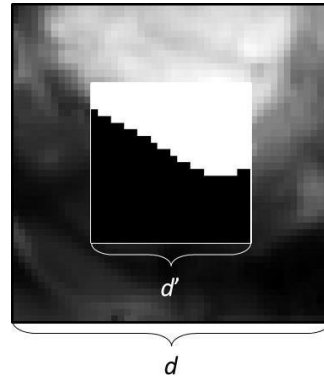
The local infrastructure for the forecast purposes the digital MRI Image feature extraction for patches with the help of side distance described as d are used to patch forecast the greatest probable label patch which is with side distance d' again in its midpoint that we select manually. Meanwhile the standard patch from the midpoint manual selected based forecast purposes that use the approaches use $d' = 1$ which shows the quantity of pixel taken the projected methodology deliberates all the standards with $1 \leq d' \leq d$.
